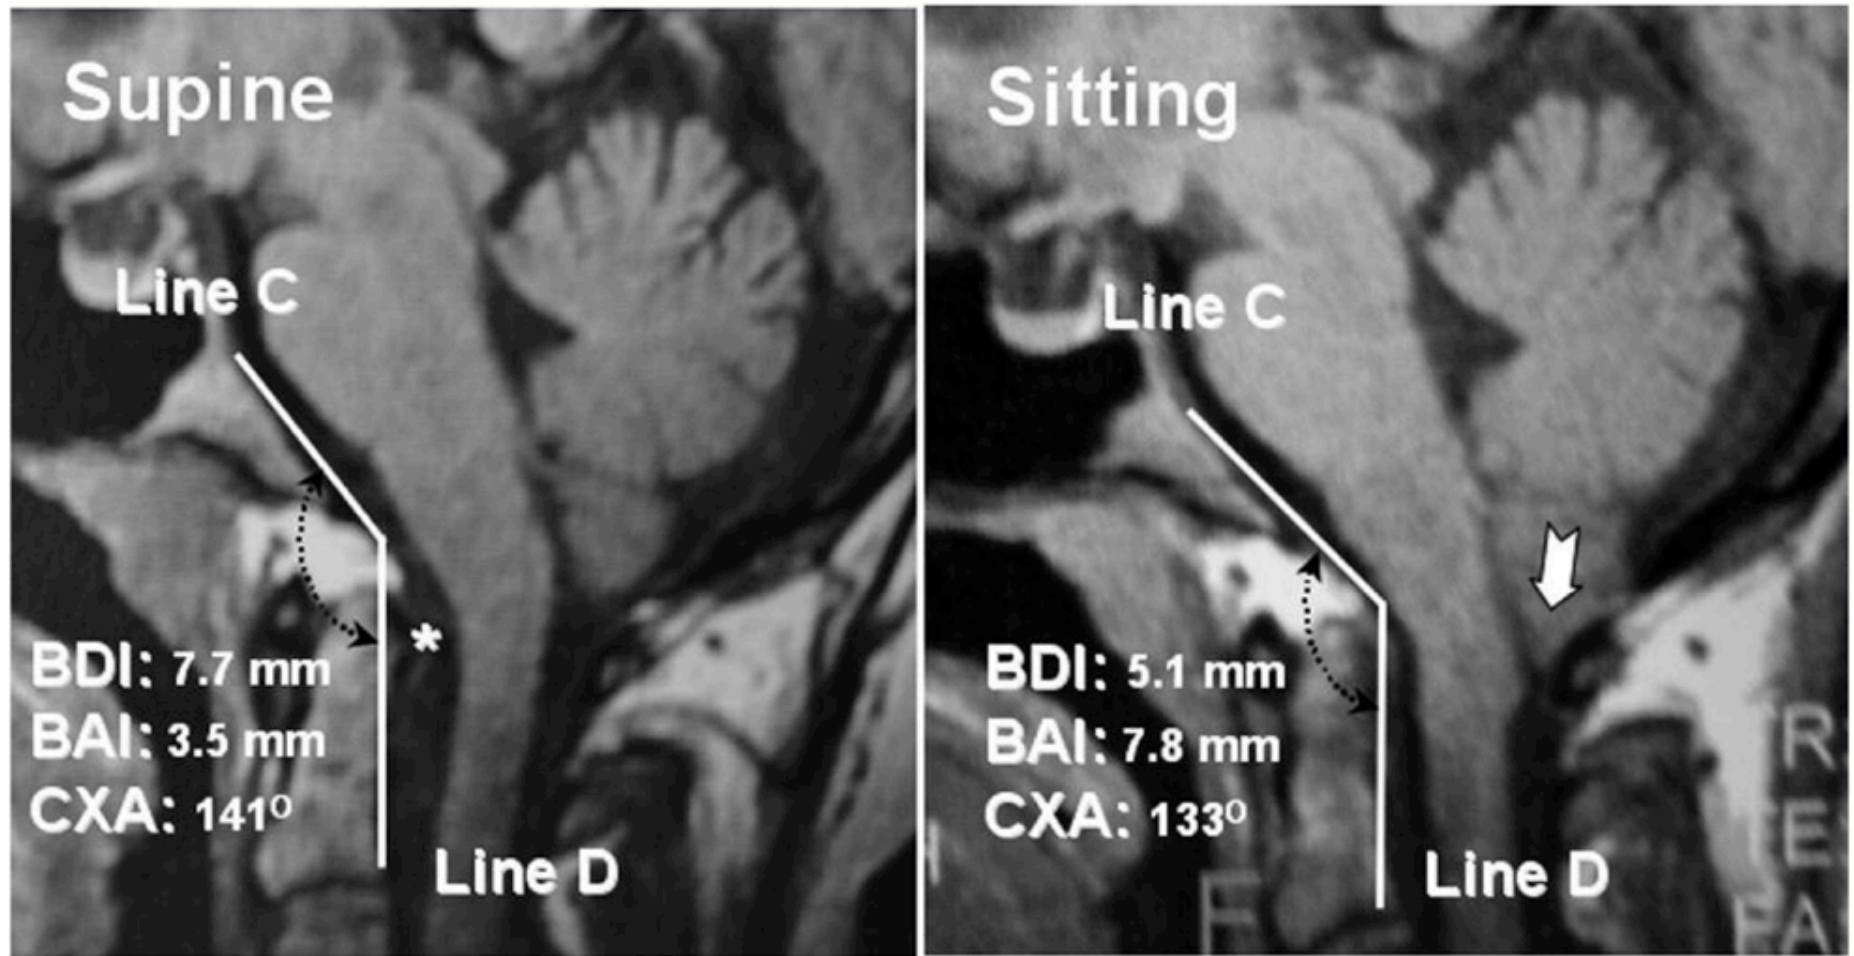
Results of vertical MR imaging in a 27-year-old woman with HDCT/CM-I. Midsagittal image in supine position (*left*) showing normal basilar cistern depth interval (7.7 mm), normal basilar
